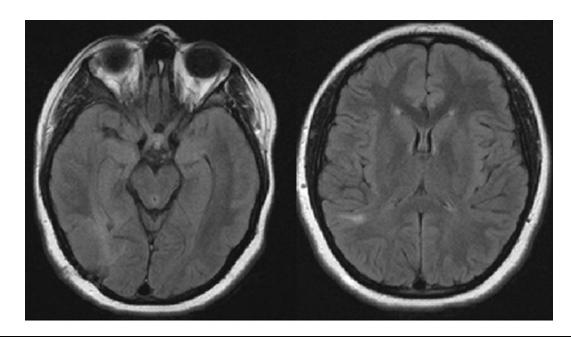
Magnetic resonance imaging 18 months after admission. FLAIR: near total resolution of the high signal intensity in the right hemispheric lesion.
